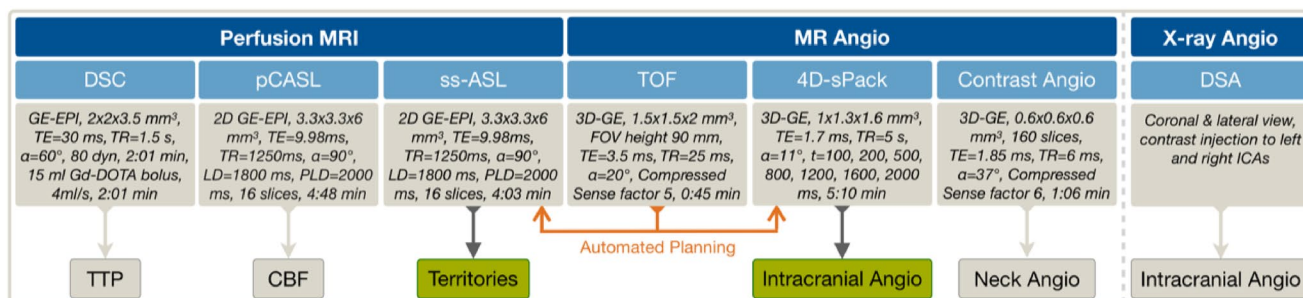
250 Imaging protocol and derived parameters. Dynamic susceptibility contrast (DSC) MRI was applied to derive time-to-peak (TTP) maps, pseudo-continuous arterial spin labeling (pCASL) for cerebral blood flow (CBF), super-selective ASL (ss-ASL) for perfusion territories and 4D-sPack for timeresolved intracranial angiography. Vessel-selective labeling was repeated for each brain feeding artery (green) and automatically planned (orange) using time-of-flight (TOF). For comparisons, MR neckangiography and digital subtraction angiography (DSA) were applied
